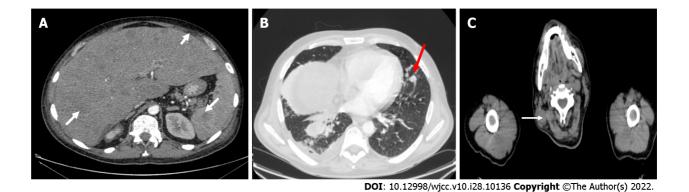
Computed tomography scan. A: Lesions in the liver, spleen, subcutaneous tissue (arrows); B: Lesions in the lungs (arrow); C: Pathological lymphadenopathy of the neck (arrow).
